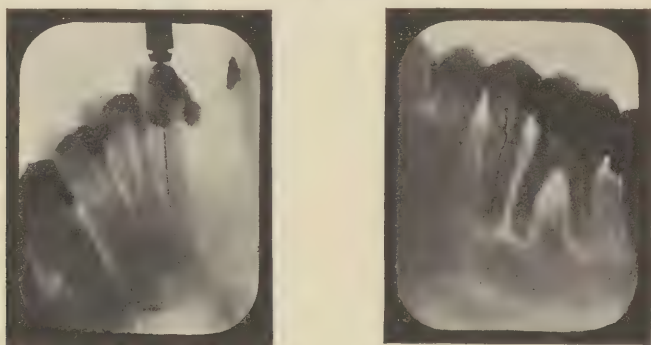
Radiographs showing wires in root-canals.
